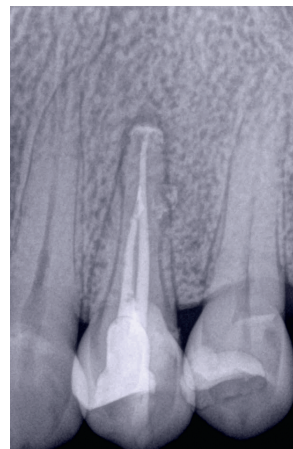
Re-evaluation at 5 months, the periapical areas are seen to be in the process of healing; part of the cement has been resorbed by the organism.
